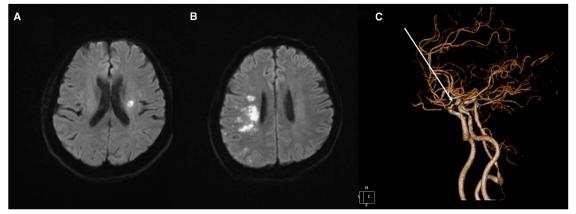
Representative brain images of lacunar infarction (A) and large artery atherosclerosis (LAA) (B, C). Lacunar infarction was defined as having a pathologic lesion less than 20 mm on diffusion-weighted imaging (DWI) magnetic resonance imaging scans (A) and LAA was diagnosed as having DWI lesions (B) with either significant stenosis (>50%) or occlusion of a relevant major or cortical branch artery (C, white arrow), presumably resulting from atherosclerosis.
